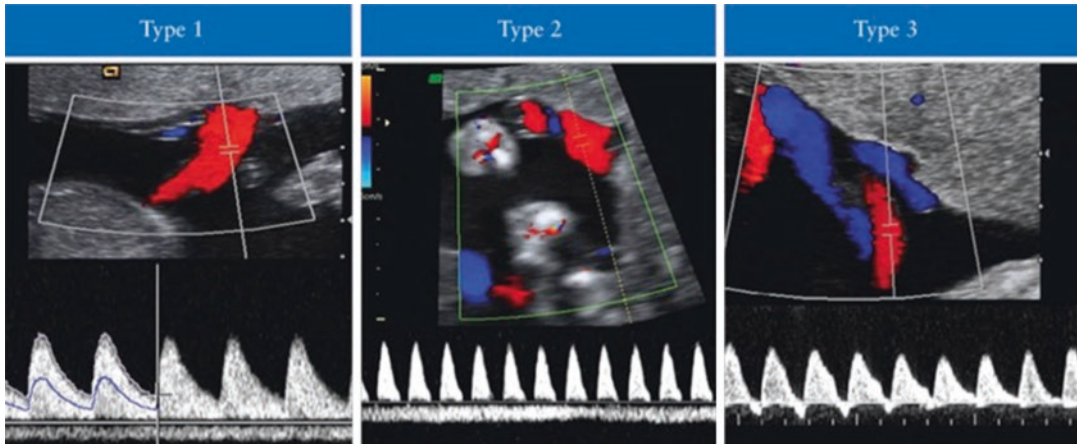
Classification of selective fetal growth restriction in MCDA twin pregnancy using umbilical artery Doppler. Type I—positive end-diastolic flow; type II—
